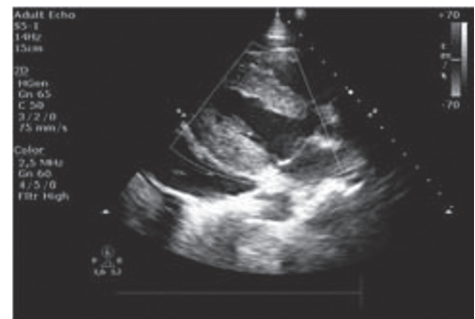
Echocardiography with evident pericardial effusion (20-25 mm).
